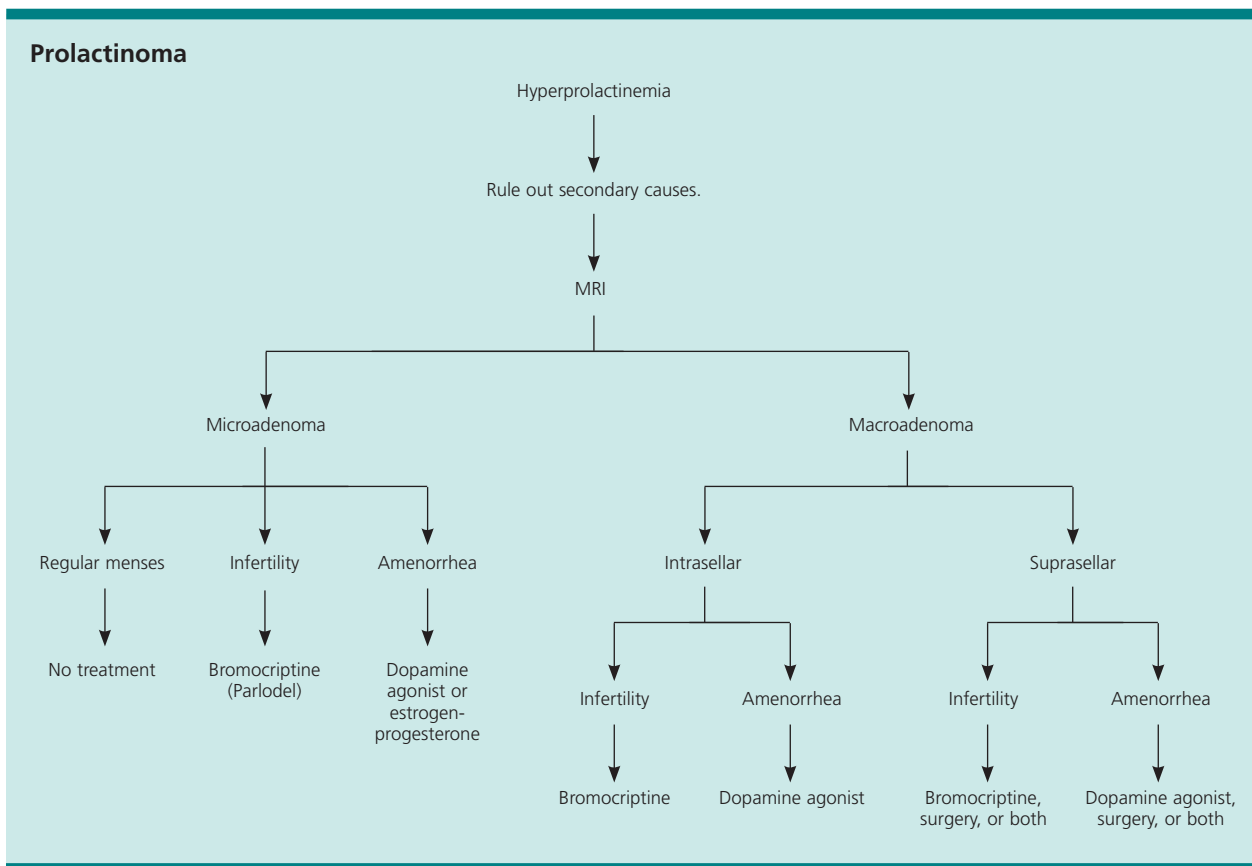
Algorithm for the management of prolactinoma in women. (MRI = magnetic resonance imaging)
